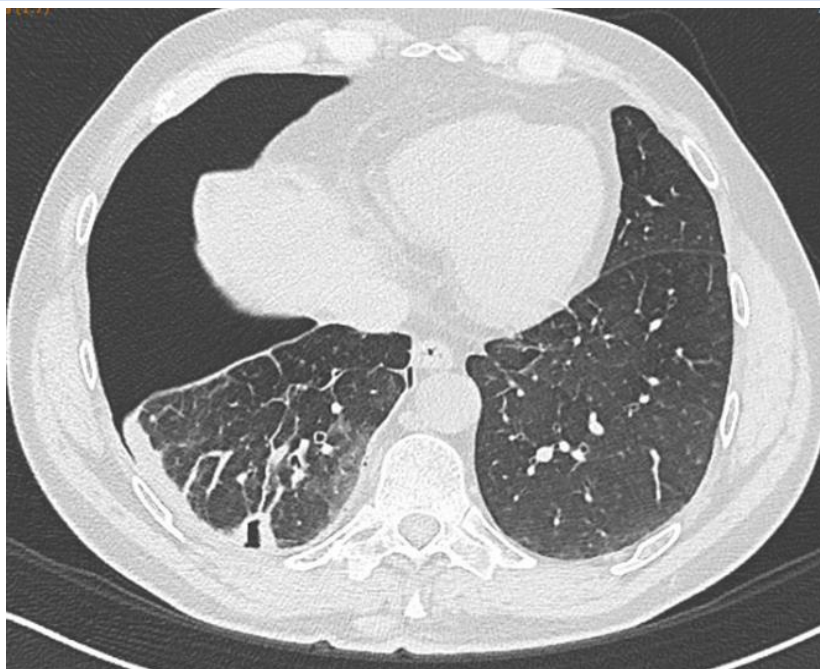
Chest CT-scan demonstrating (demonstrates) right pneumothorax with pleural thickening and dense scar tissue surrounding pulmonary breach in the area of resected metastasis
